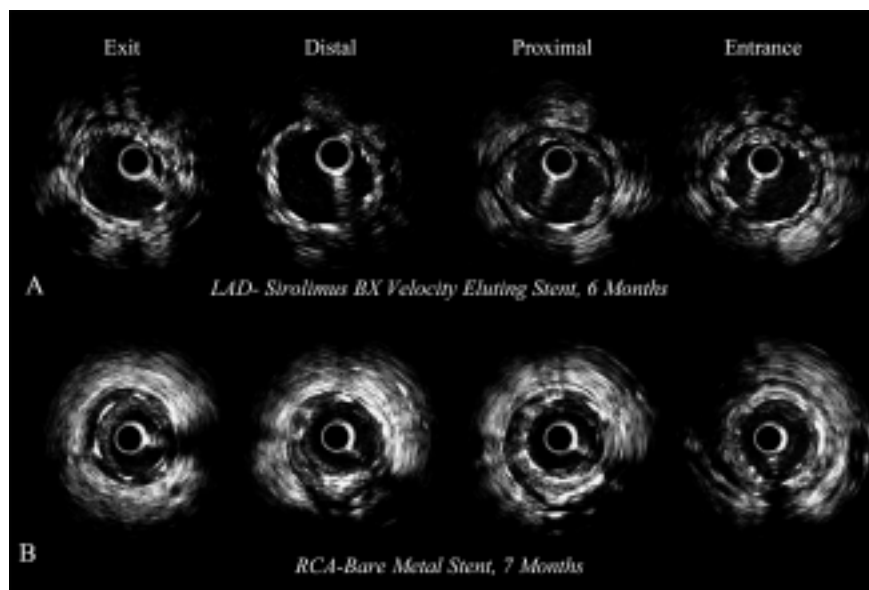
Six-month intravascular ultrasound follow-up at different sections from the distal to the proximal reference segments. Four in-stent cross-sections (entrance, proximal, distal, exit) are shown. A: sirolimus-eluting stent, absence of neointimal growth across all the intravascular ultrasound sections. B: the 7-month intravascular ultrasound images of the Multi-Link™ bare metal stent implanted in the right coronary artery (RCA) are shown at the corresponding sections. Mild neointimal proliferation at the exit and across the distal and proximal sections. LAD = left anterior descending coronary artery.
